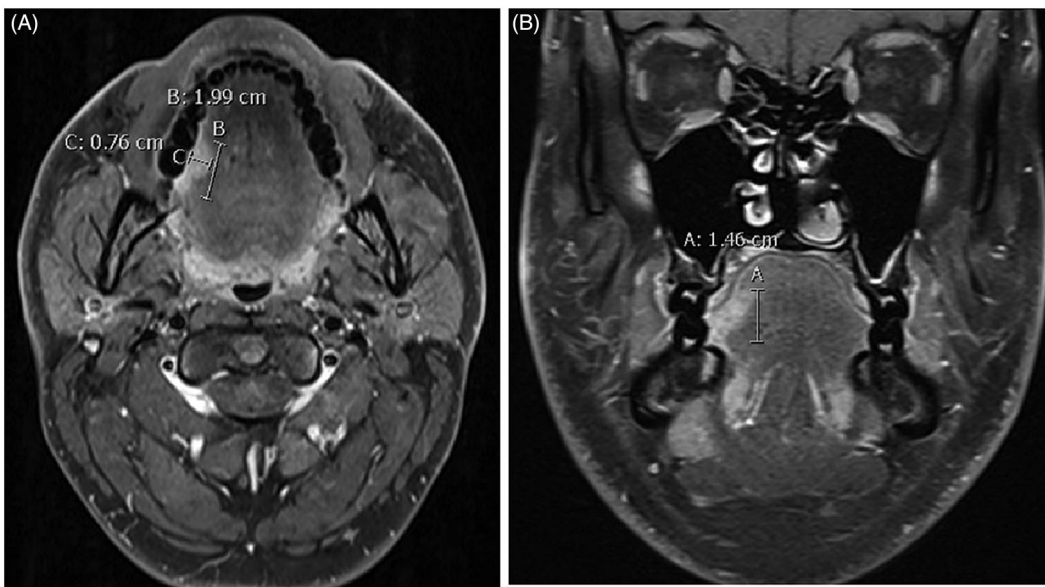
Tumor dimensions were measured from axial (A) and coronal (B) T1-weighted fat-suppressed contrast-enhanced MR images. MR: magnetic resonance; cm: centimetre.
